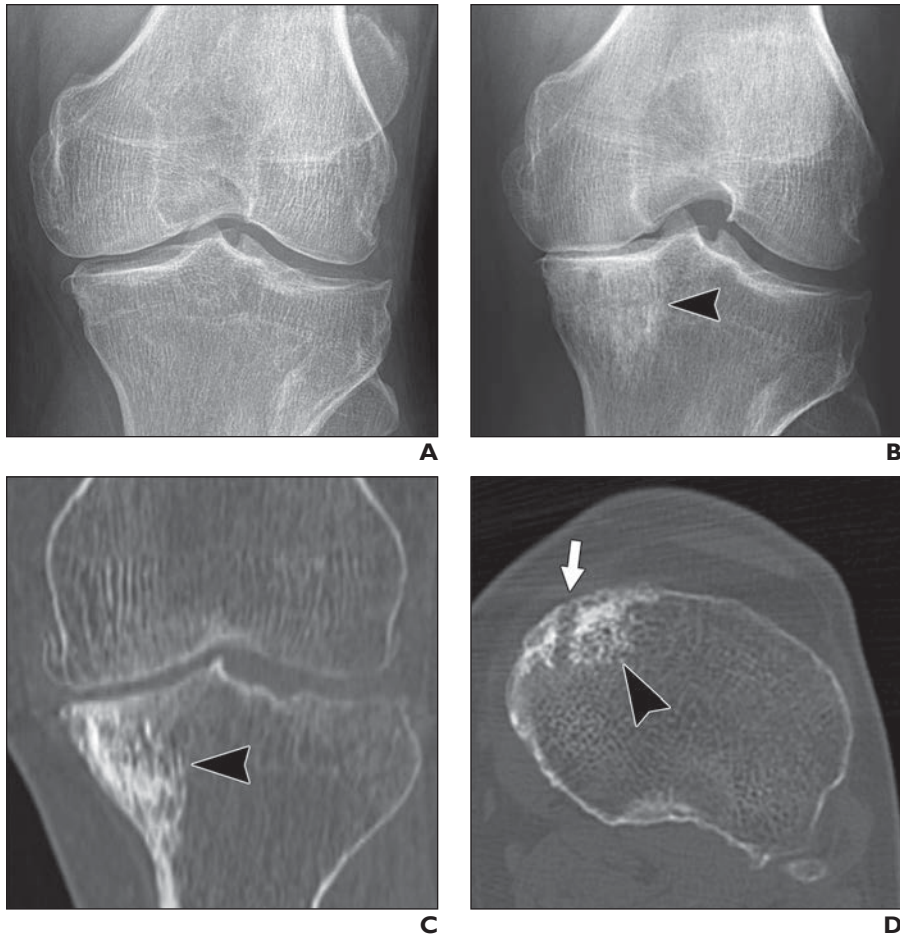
54-year-old man with left-sided knee pain. A and B, Preoperative (A) and postoperative (B) radiographs are shown. After subchondroplasty, there is focal increased density in medial tibia plateau (*arrowhead, B*) where calcium phosphate was injected. C and D, Injected calcium phosphate (*arrowhead*) is also well depicted on coronal (C) and axial (D) CT images that were acquired 2.5 years after subchondroplasty for preoperative planning of medial unicompartmental arthroplasty (MAKOplasty, MAKO Surgical) due to persistent knee pain. Drill hole (*arrow, D*) is visible on axial image; needle for subchondroplasty was placed via anterior approach.
